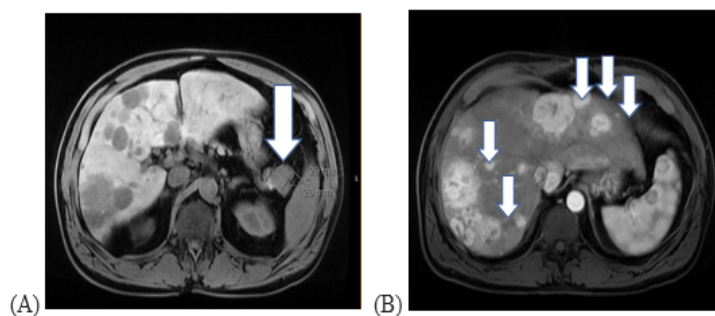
Triphasic MRI of abdomen and pelvis demonstrating pancreatic mass (A) and multiple hyper vascular liver lesions (B).
